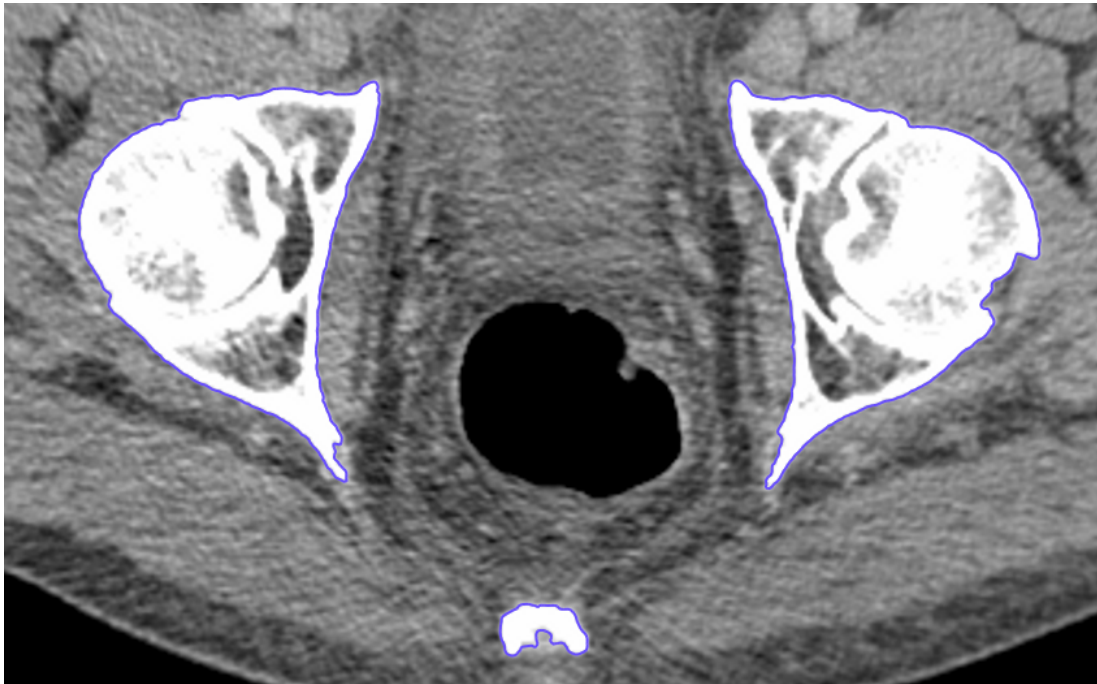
An example of a typical segmentation with the segmented bone being outlined in purple. The underlying CT data is from the Addenbrooke's Hospital CT Data Collection.
